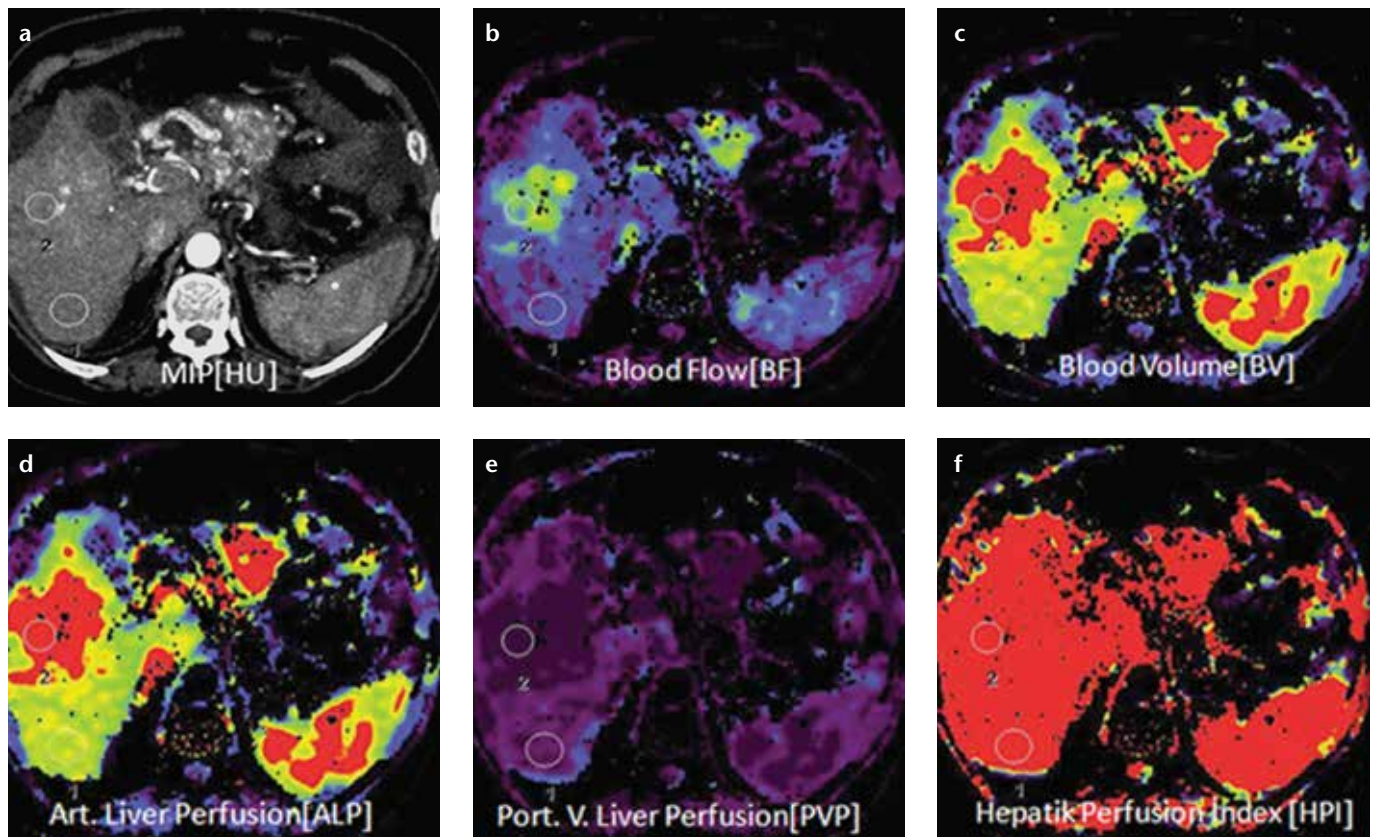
a–f. Axial perfusion images (a) and functional CT perfusion map (b–f) of a 60-year-old man with hepatocellular carcinoma in the right lobe of the liver. The tumor manifests as a distinct range of colors compared with the background liver parenchyma. The functional map shows the wash out in the tumor. ALP, arterial liver perfusion; BF, blood flow; BV, blood volume; HPI, hepatic perfusion index; MIP, maximum intensity projection; PLP, portal liver perfusion.
